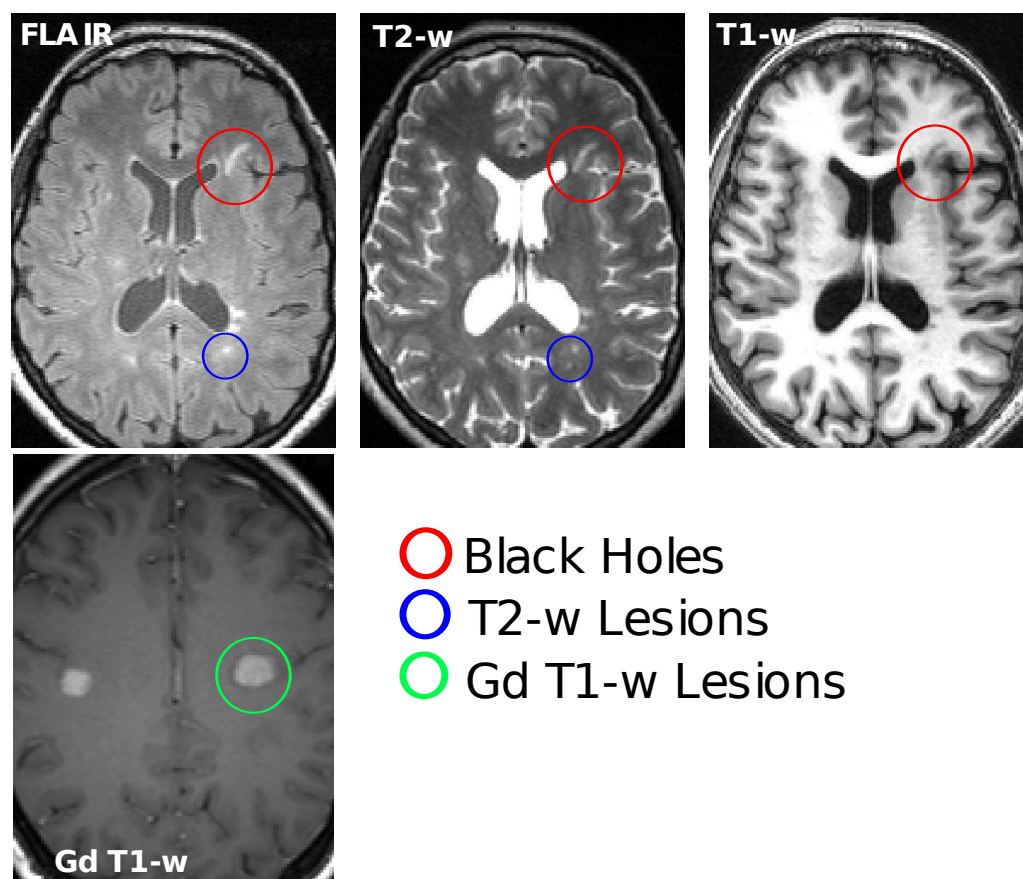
Exemples des lésions de SEP en IRM: T1-w, T2-w, FLAIR and T1-w avec contraste en Gadolinium.
